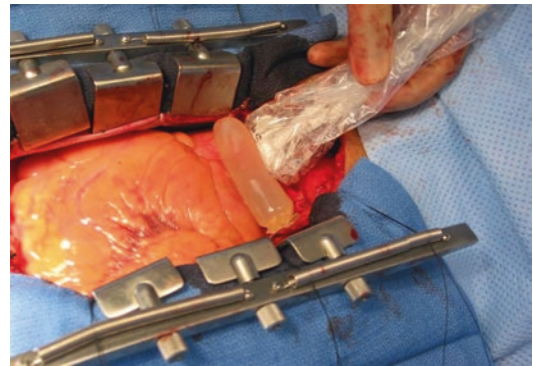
Epiaortic echocardiography. The echo probe is placed directly on the aorta at the time of surgery, with an interposed fluid-filled interface (the tip of a sterile glove) (Reprinted with permission from [1])
